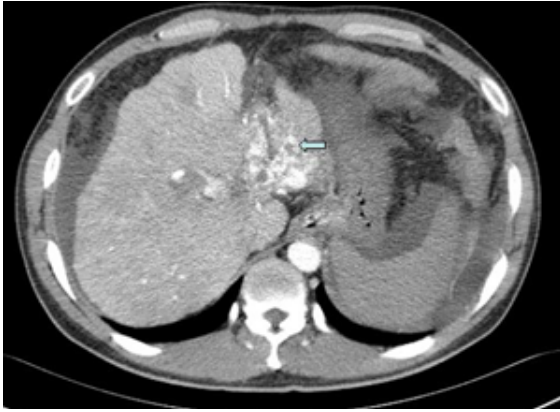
Tumor thrombus at left PV with massive AP shunt(open arrow) is noted on early arterial phase of postenhanced CT.
